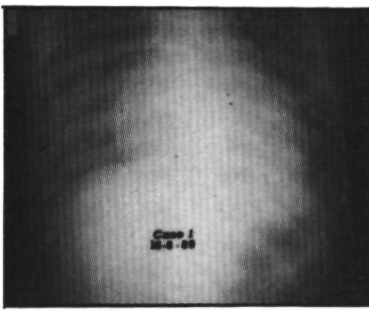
(Case 1). Chest roentgenogram: posteroanterior view. Left, generalized cardiomegaly and pulmonary vascular congestion on day of admission. Right, disappearance of pulmonary vascular congestion and decrease in heart size ten days later.
